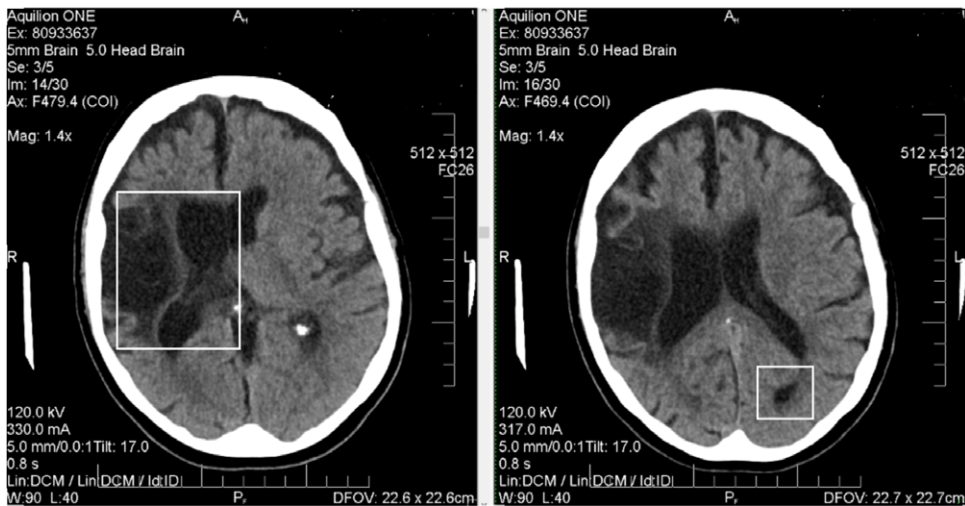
Computed tomography (CT) scan (identifying information blacked out). The damage from the earlier middle cerebral artery stroke with *ex vacuo* dilation of the right lateral ventricle can be seen on the left image. The image on the right highlights the more recent stroke in the posterior parietal region, which may have contributed to perceptual disturbance.
